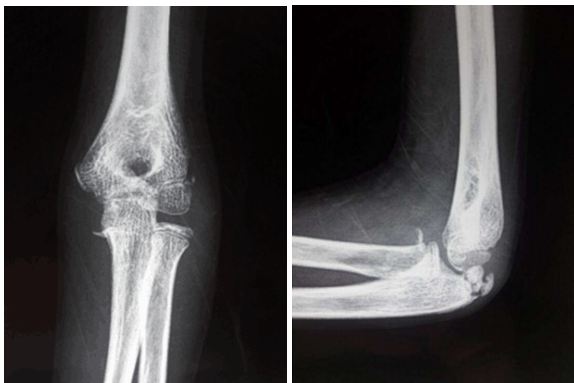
Four week post-operative X-rays showing the initiation of healing of the olecranon.
